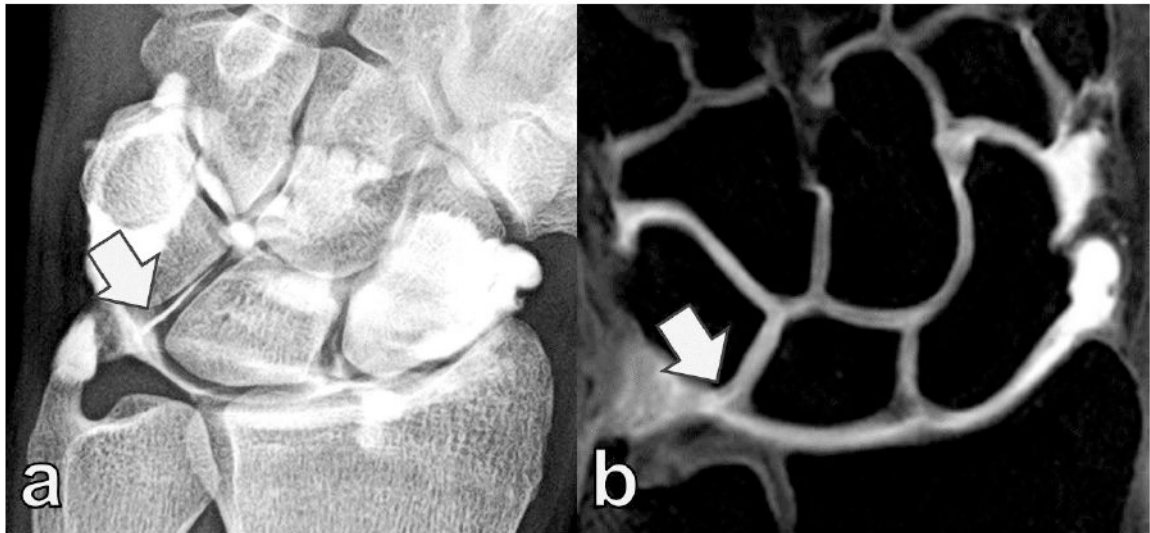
Examples of type I (a) and type II (b) lunates as seen on coronal T1-weighted MR arthrogram; arrows point to the absence and presence of an additional articular facet on the lunate, respectively
